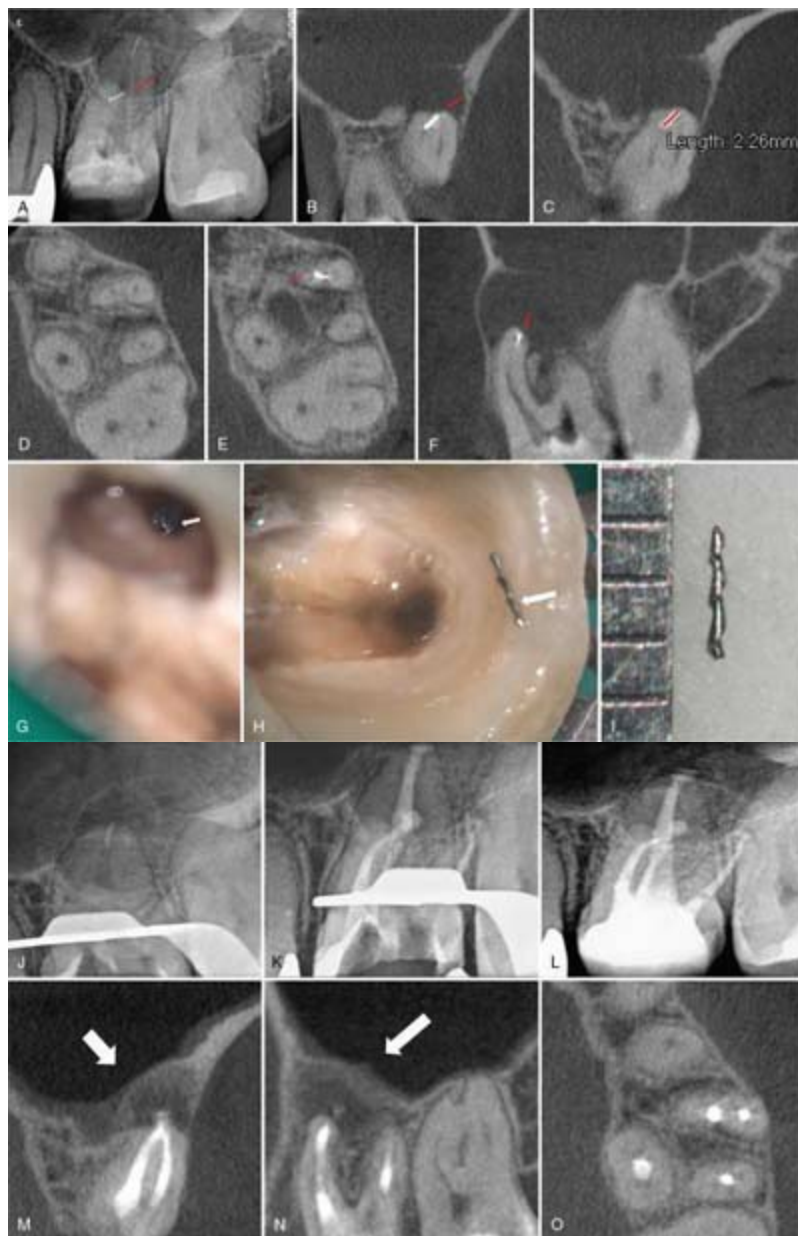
A, Preoperative radiograph of a maxillary left first molar showing a separated instrument beyond the curve in the mesiobuccal root canal with large periapical lesions (*red arrow*). B, Coronal view of cone-beam computed tomography (CBCT) shows the separated instrument in the buccally curved MB2 canal with a large periapical lesion developing into the sinus floor (*red arrow*). C, Separated instrument measures 2.26 mm on the coronal view. D and E, Axial view shows the separated instrument in the MB2 canal directed toward the MB1 canal. F, Sagittal view shows the separated instrument in the MB2 canal lying in a distal direction with a large periapical lesion (*red arrow*).
